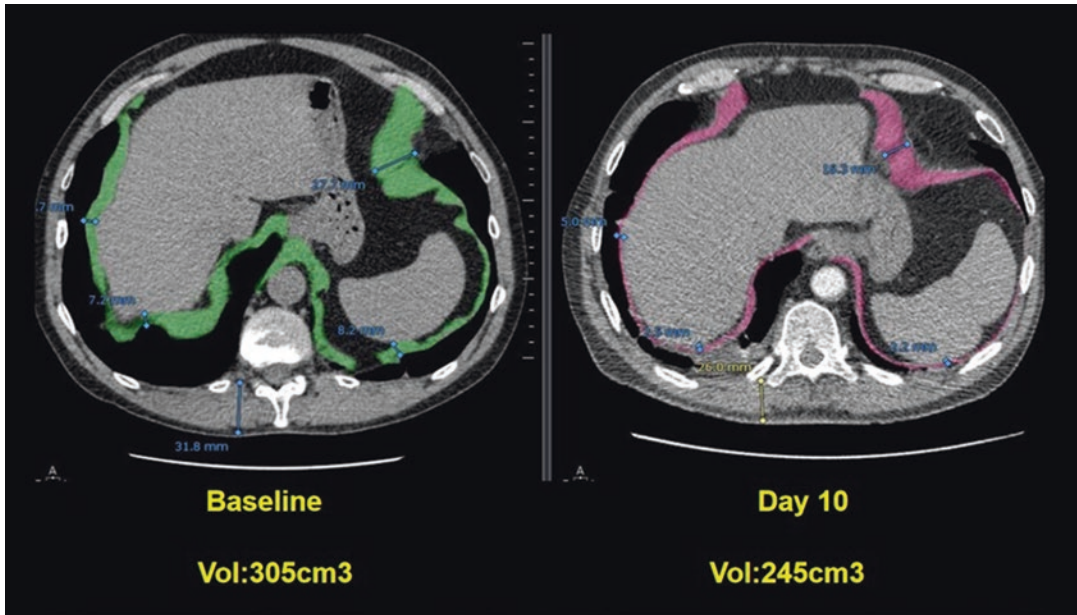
Computed tomography measurements of diaphragmatic volume in a critically ill, septic patient on admission to the intensive care unit (*left panel*) and 10 days later (*right panel*). Sepsis was associated with a
